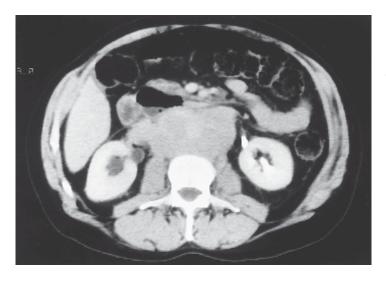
Retroperitoneal fibrosis. A tumor-like periaortic mass of homogeneous reactive fibrosis pulls the ureters medially in this contrasted computed tomography scan of the abdomen and retroperitoneum in a patient with retroperitoneal fibrosis.
